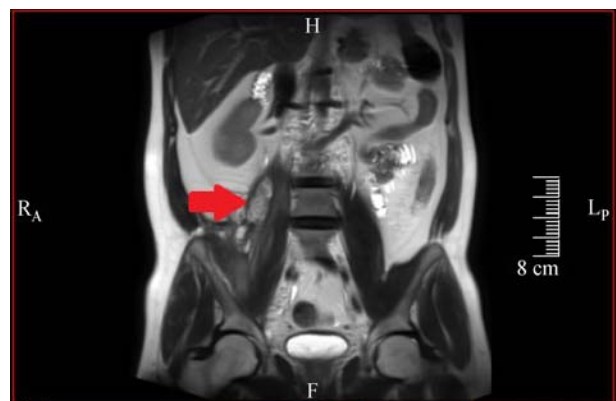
MRI shows residual right retroperitoneum collection (arrow) measuring 6 cm × 1.5 cm with residual right psoas and iliacus muscle inflammatory changes.
